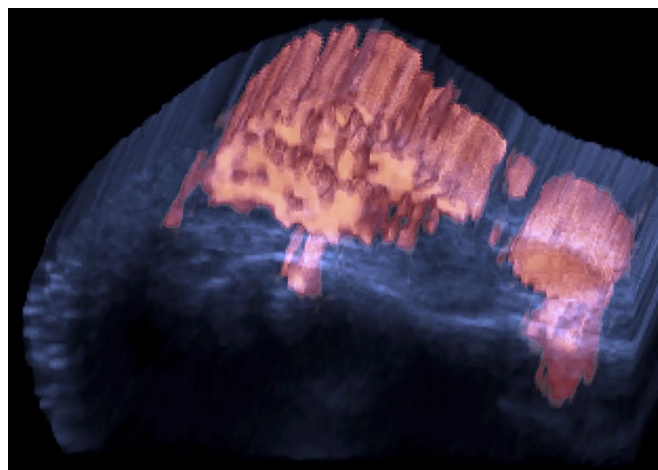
Three-dimensional reconstruction of the power Doppler scan of a nasal telangiectatic granuloma.
